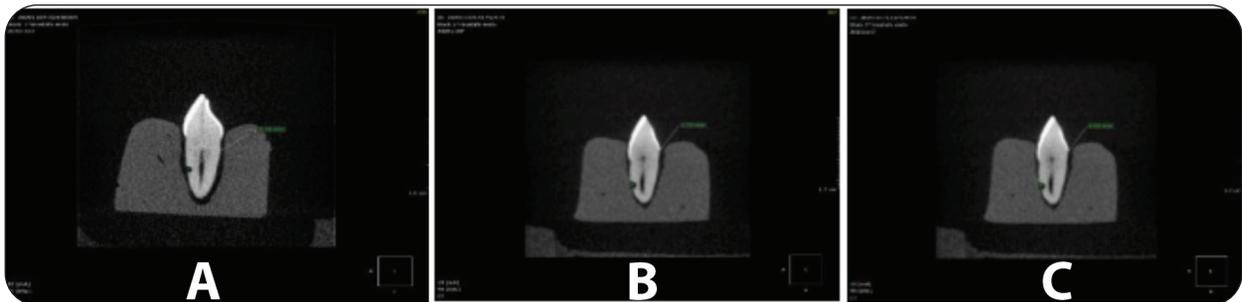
CBCT image showing axial view A shallow cavity in the middle of the root B moderate cavity in the middle of the root C large cavity in the apical third of the root.
